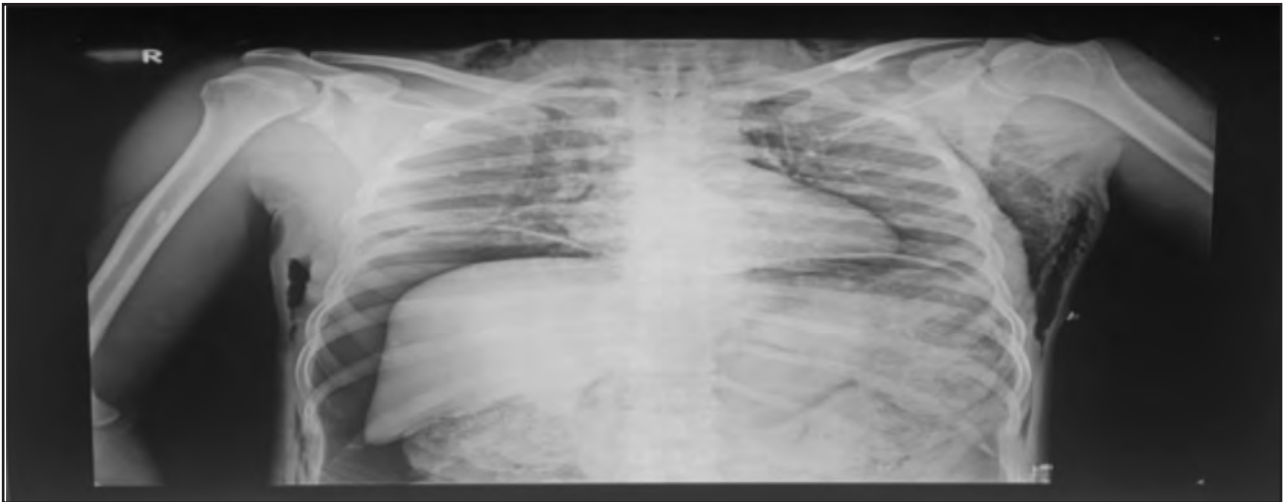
Chest xray showing air under diaphragm indicating and hollow viscus perforation
